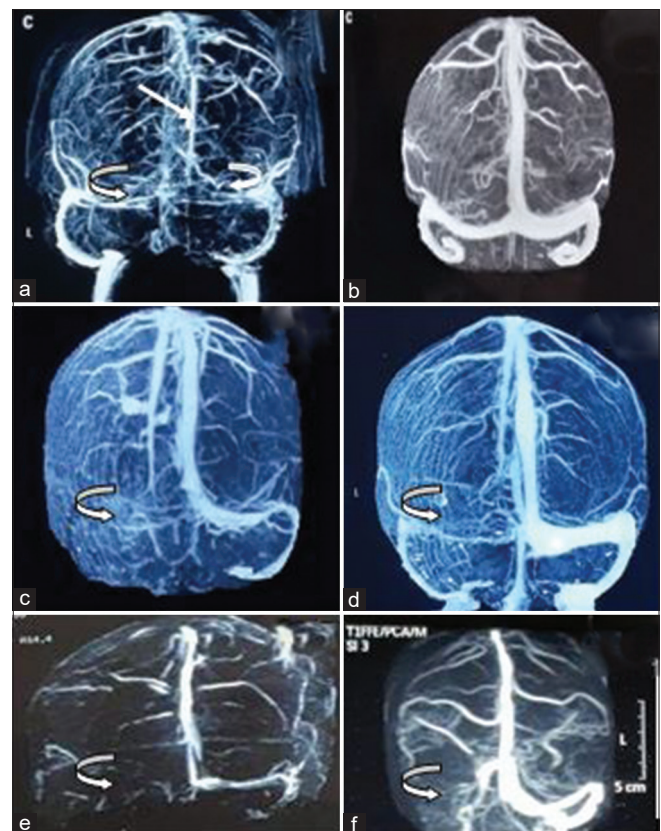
a CT venogram: Superior sagittal sinus thrombosis (straight arrow) with bilateral transverse sinus thrombosis (curved arrow) and right sigmoid sinus thrombosis, b: Complete recanalization of all thrombosed sinuses, c: CT venogram: Left transverse and sigmoid sinus thrombosis (curved arrow), d: Partial recanalization of thrombosed sinuses, e: MR venogram: Right transverse and sigmoid sinus thrombosis (curved arrow), f: No recanalization of sinuses
